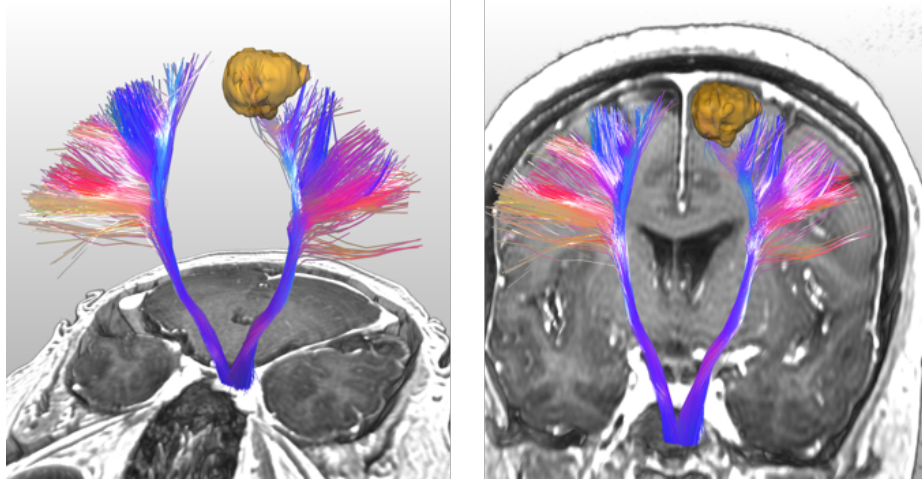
Patient 1: Tracked fibers of the corticospinal and corticobulbar tract with a volume rendering of T1-weighted image data.
